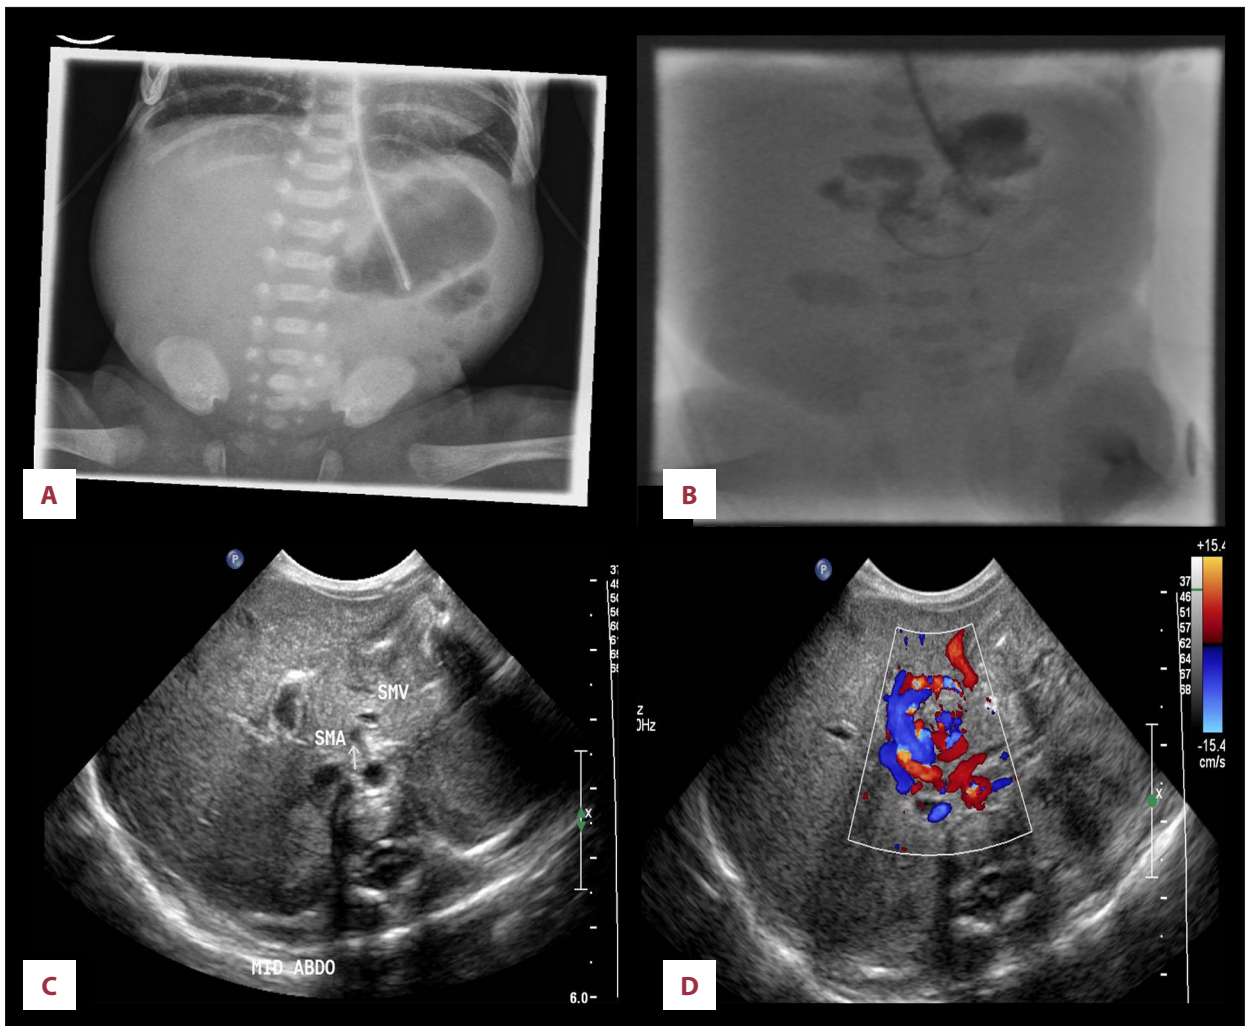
(A-D) Abdominal radiograph and upper-GI contrast study suggest high-grade obstruction at level of proximal duodenum. US findings suspicious for malrotation.
